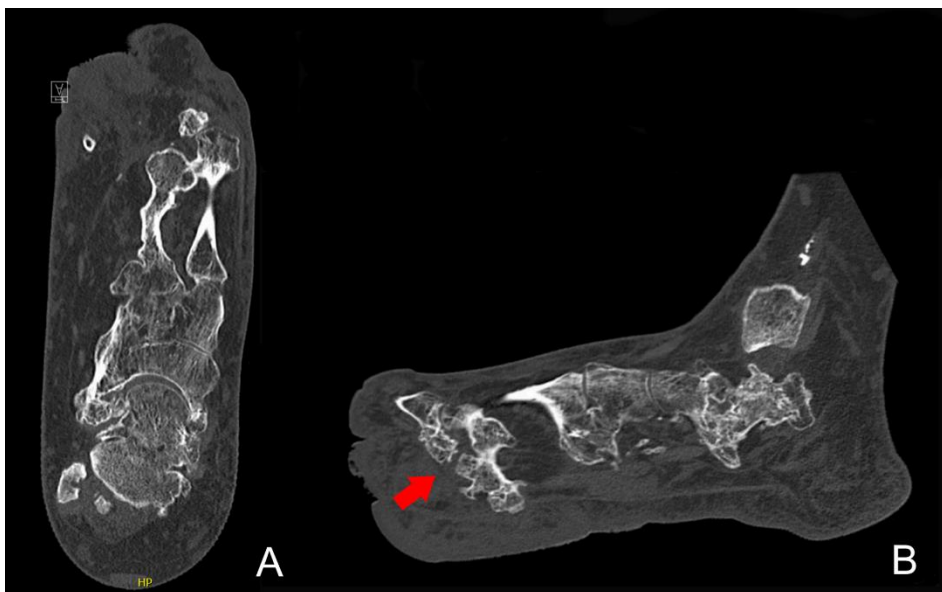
CT-scan of the left foot of case 1. 3A: Transversal view showing a synostosis between metatarsal I and II. 3B: Sagittal view with a visible bone spur from metatarsal II towards the plantar side (arrow).
